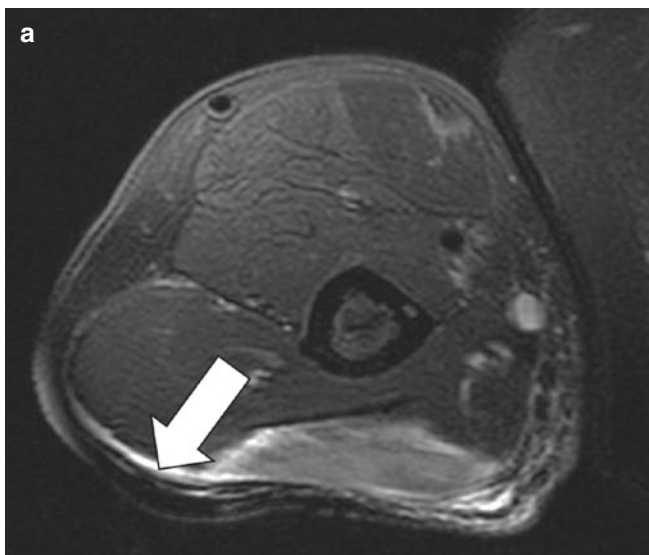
Fat-saturated STIR MR images of the upper right arm (a) and right thigh (b) in a 27-year-old patient with dermatomyositis. Notice the perimysial pattern of edema with preferential involvement of the superficial fascia (white arrow) and myotendinous junction (black arrow)
